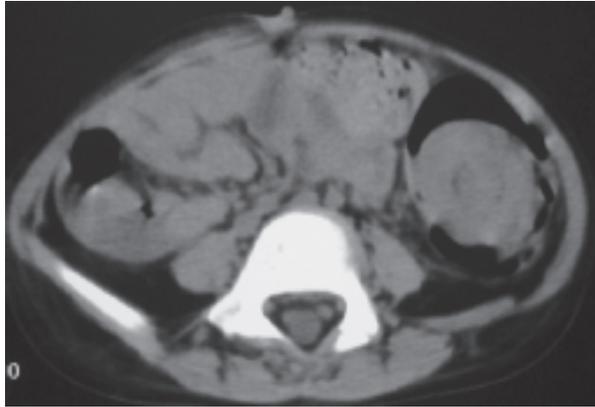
A 56-year-old man with an colocolic intussusception due to descending colon adenocarcinoma. Non contrast CT scan of abdomen shows typical appearance of a large bowel intussusception. The intussusceptum (black arrow) is surrounded by a thick walled intussusciptum (white arrow).
